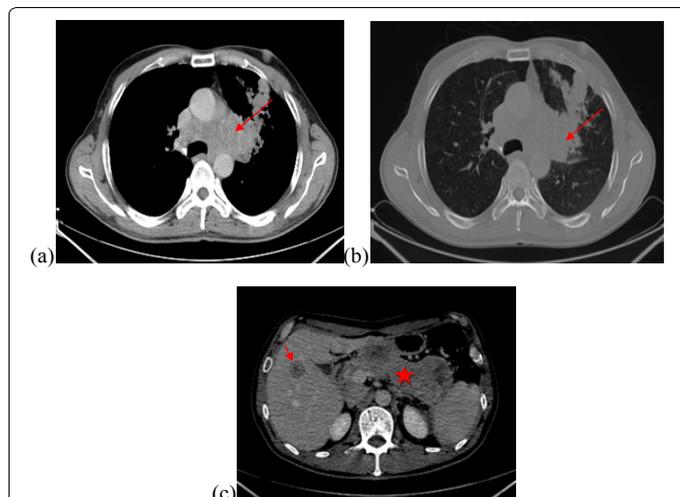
Enhanced CT scan of chest and abdomen in axial plan showing mediastino-pulmonary tumor (1a and 1b) and secondary pancreatic and hepatic lesions (1c).
